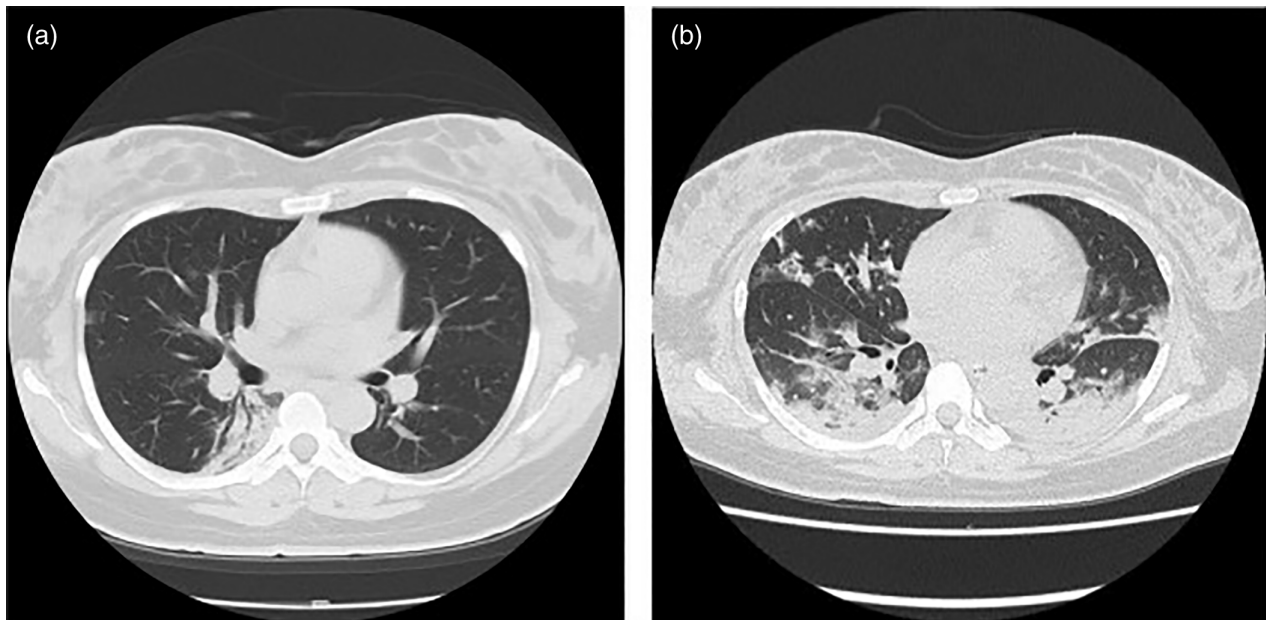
Chest computed tomography. (a) Image on day 6 of week 25. Infiltrative opacity can be seen in the peripheral regions of the right lower and upper lobes, along with lung field volume loss. (b) Image after completing surgery. Ground-glass opacity expansion in both lungs and abnormal opacity expansion can be seen, indicating that an air bronchogram is present in the left internal regions of the lower lobes of both lungs.
